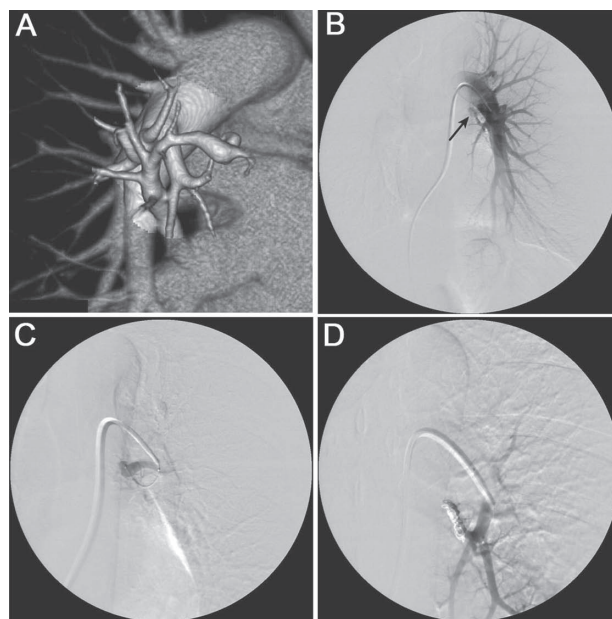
Embolization of a PAVM with a short feeding artery. Left pulmonary angiogram of a 48-year-old woman. A, B. A PAMV with a short feeding artery (arrow) was observed in the right S6 with 3D CT and left pulmonary angiography. C. We successfully inserted a 2.5-Fr microcatheter into the venous sac. D. We embolized the venous sac and feeding artery with detachable coils and fibered platinum coils and avoided embolization of the proximal normal branch.
